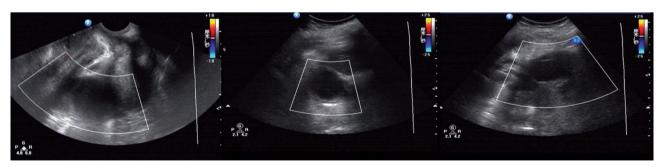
The abscess in the plevic of ultrasonic examination.
